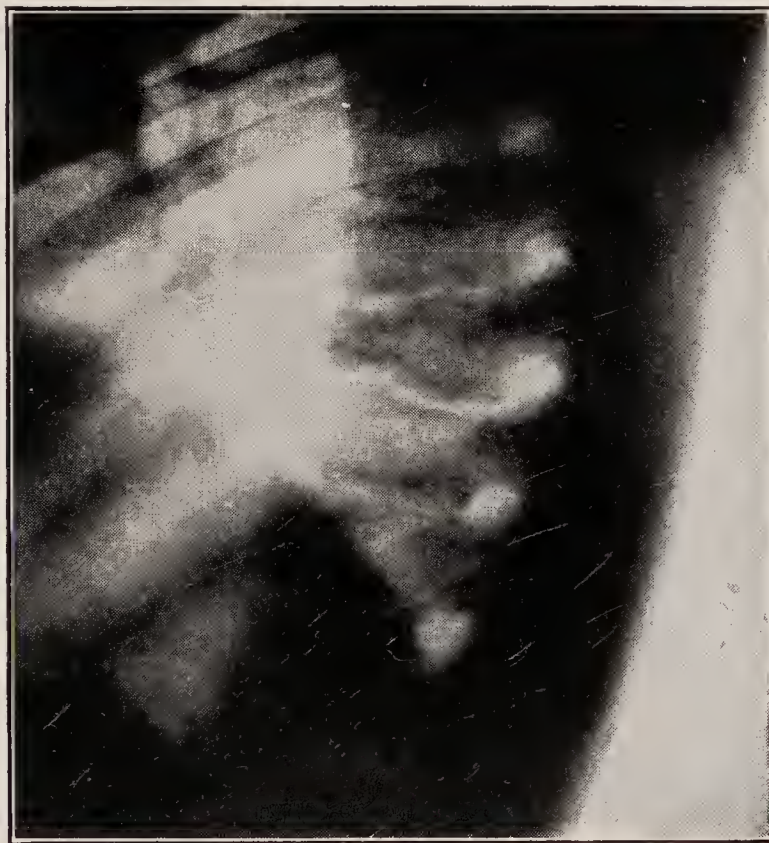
X-ray of case of actinomycosis of spine, side view.
